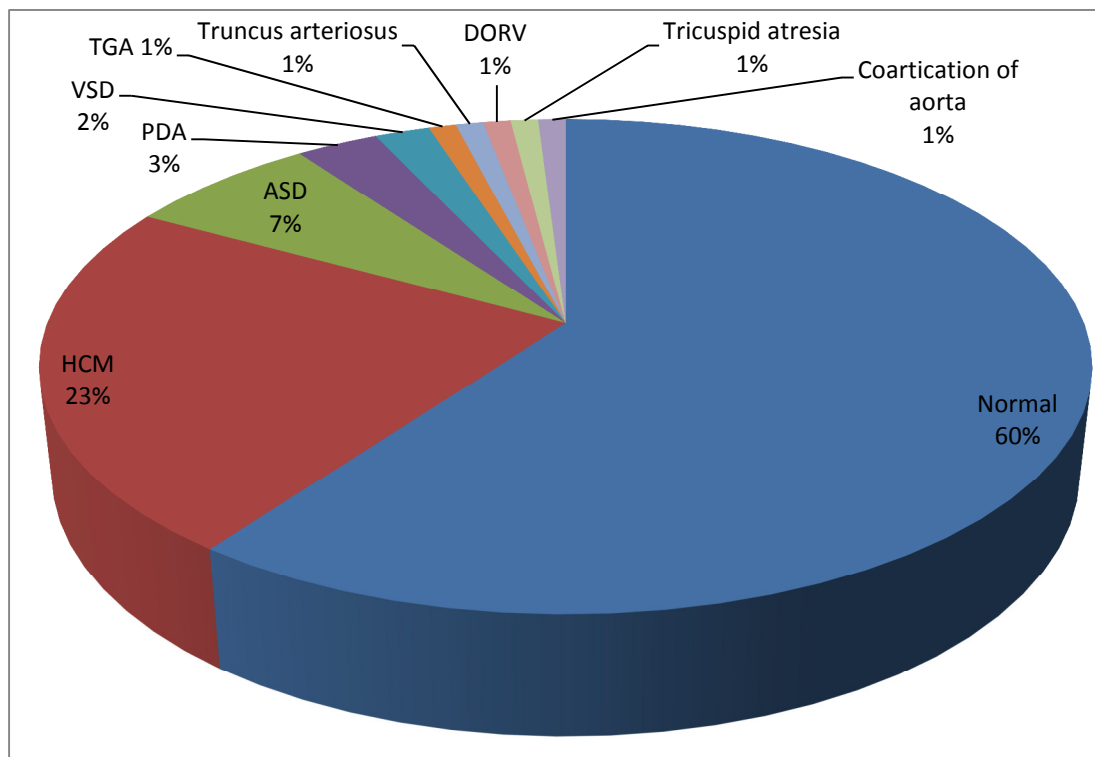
Distribution of the study sample according to Echocardiography
